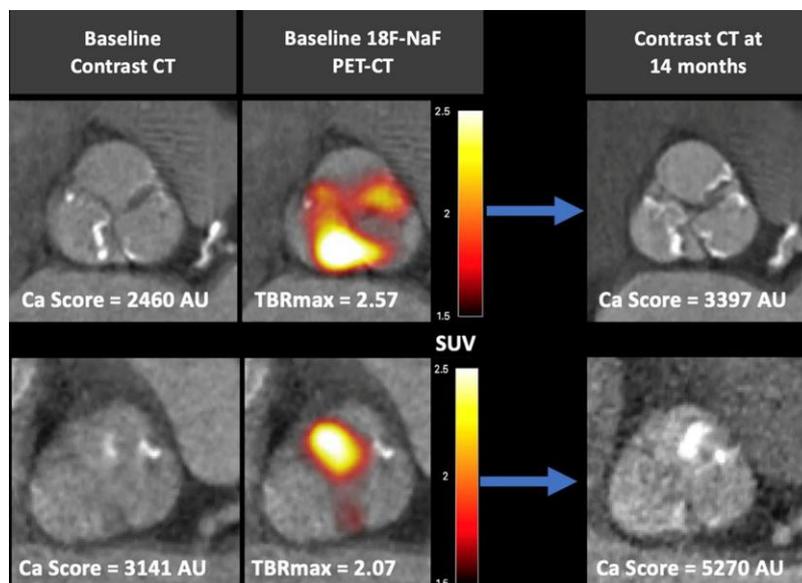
^{18}F -sodium fluoride PET-CT for aortic valve calcification. AU, Agatston units; CT, computed tomography; PET-CT, positron emission tomography-computed tomography; TBR_{max} , maximum tissue-to-background ratio. Areas of red and yellow show ^{18}F -sodium fluoride uptake on the aortic valve. Areas of maximal uptake at baseline correspond to the development of visible calcification on CT at 14 months. Taken from Fletcher & Dweck. 2021. *Journal of Nuclear Cardiology*.
